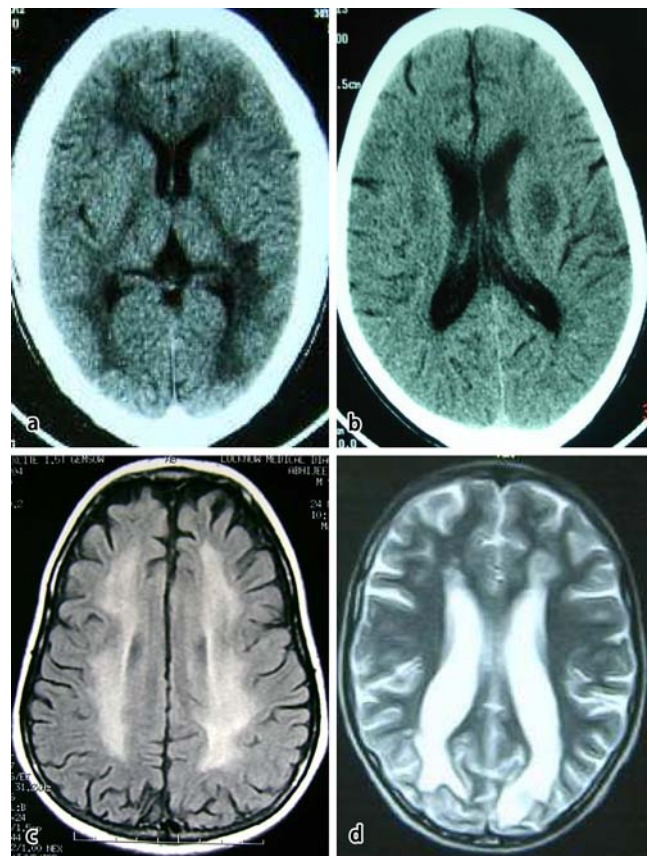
a CT of brain showing white matter abnormalities in periventricular and subcortical regions of the cortex. b CT of brain showing involvement of basal ganglion. c Axial fluid attenuated inversion recovery MR image showing increased signal abnormalities in periventricular and subcortical white matter. d T2-weighted MR image showing increased signal abnormalities in white matter and gray matter of parieto-occipital regions
